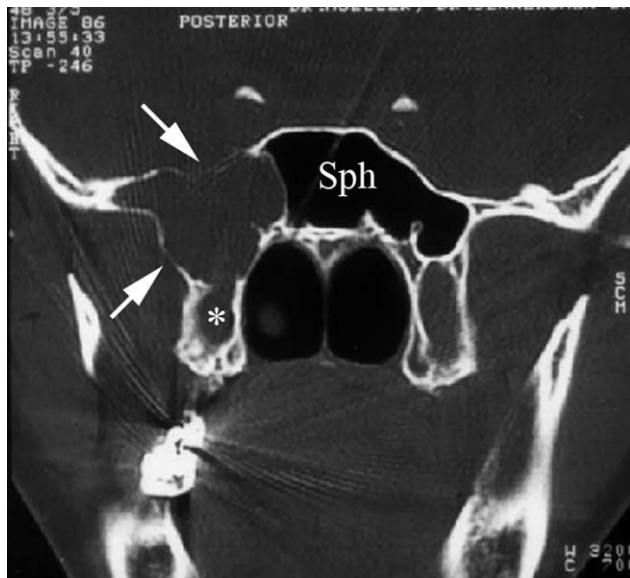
Coronal computed tomography scan showing a well-pneumatized sphenoid sinus and its surroundings. The bony wall of the sinus reveals defects (arrows) on the right side. Sph = sphenoid sinus, * = pterygoid process.
